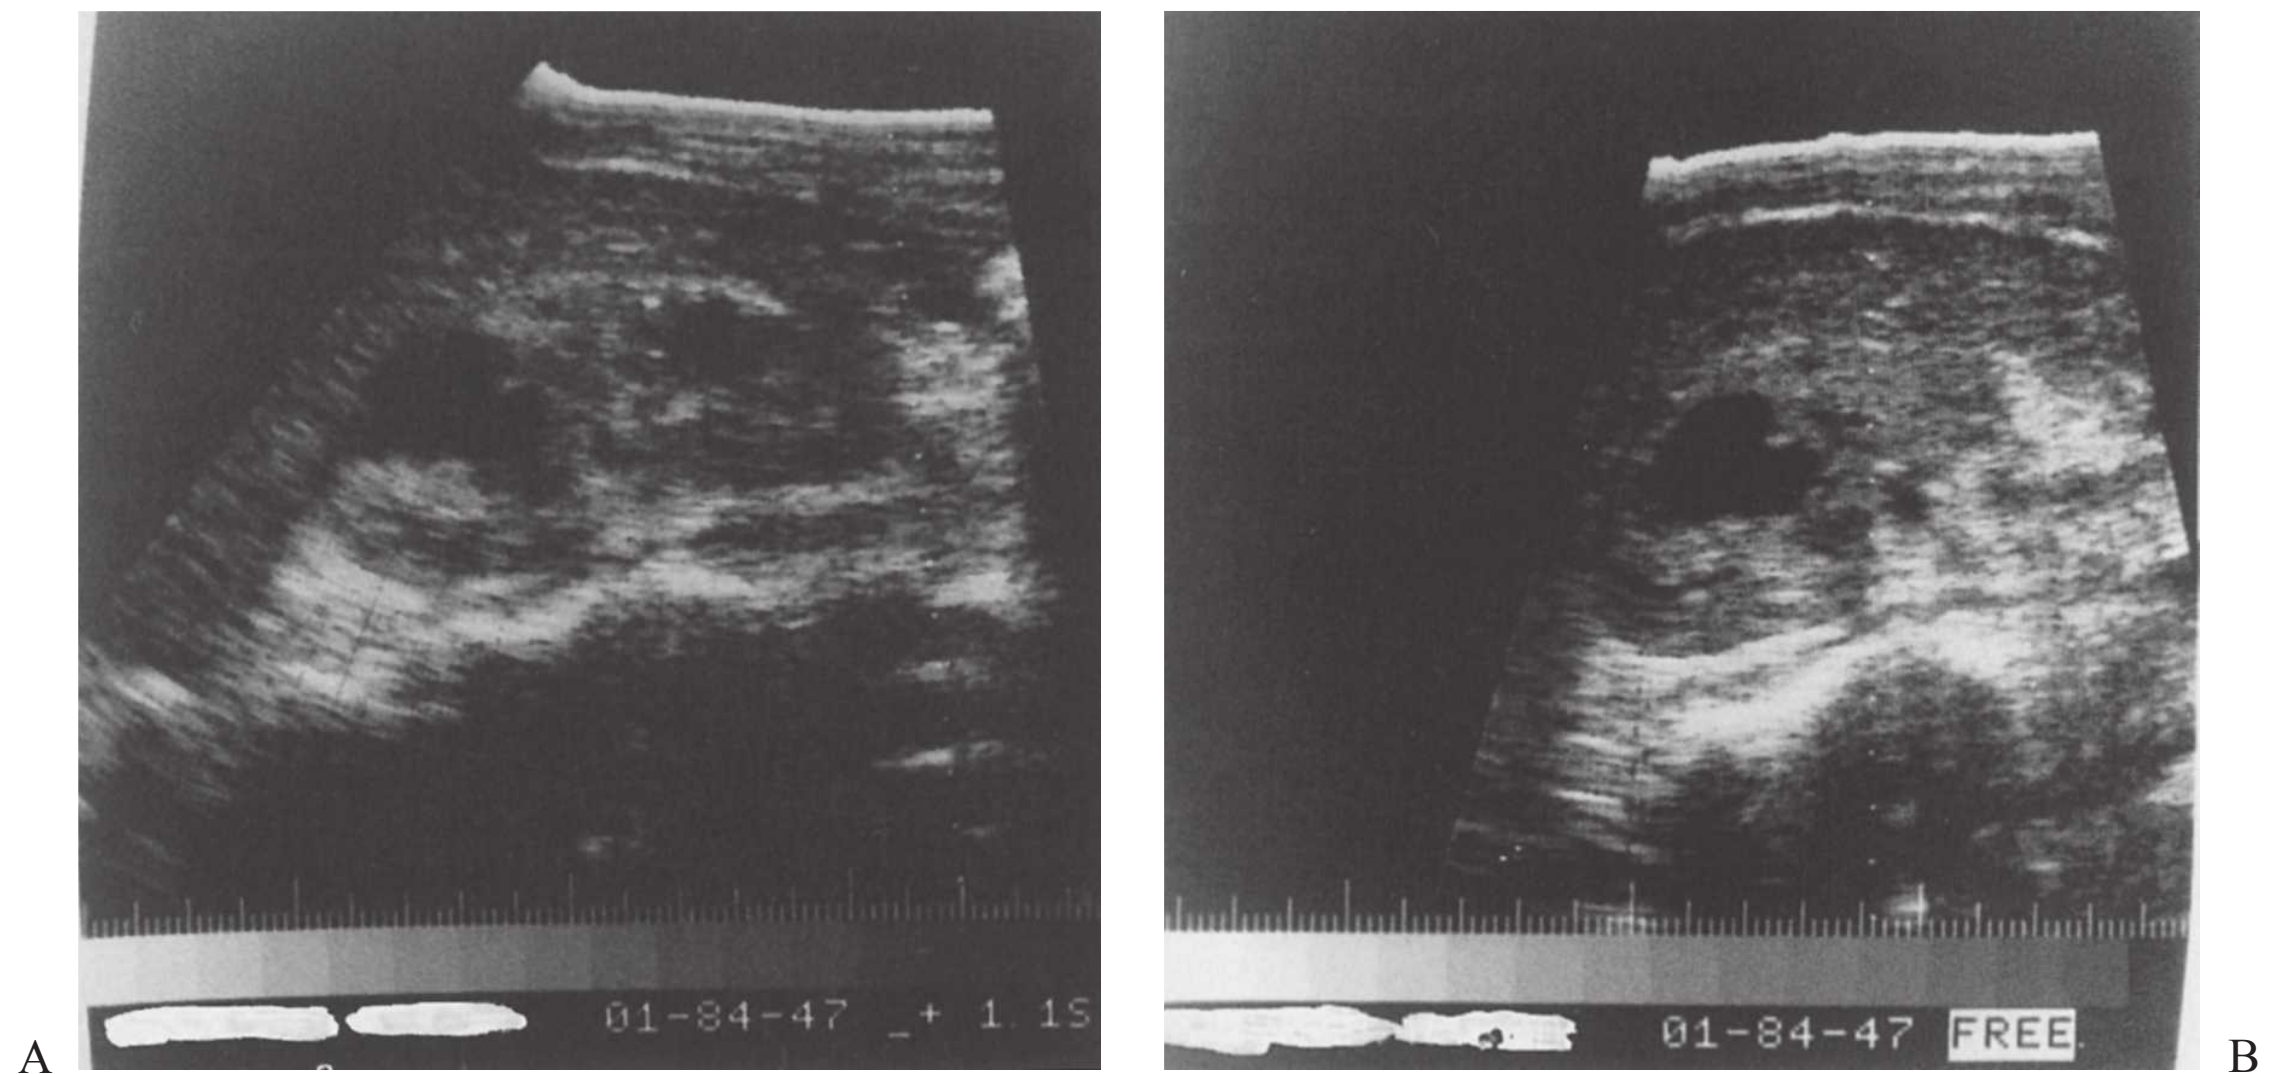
Ultrasonogram of the right kidney on admission to the hospital. A: Longitudinal view, demonstrating two echolucent fluid-filled lesions. B: Transverse view, demonstrating fluid-filled masses with thickened margins. (From Andriole VT. Renal carbuncle. *Medical Grand Rounds*. 1983;2:259, with permission.)
